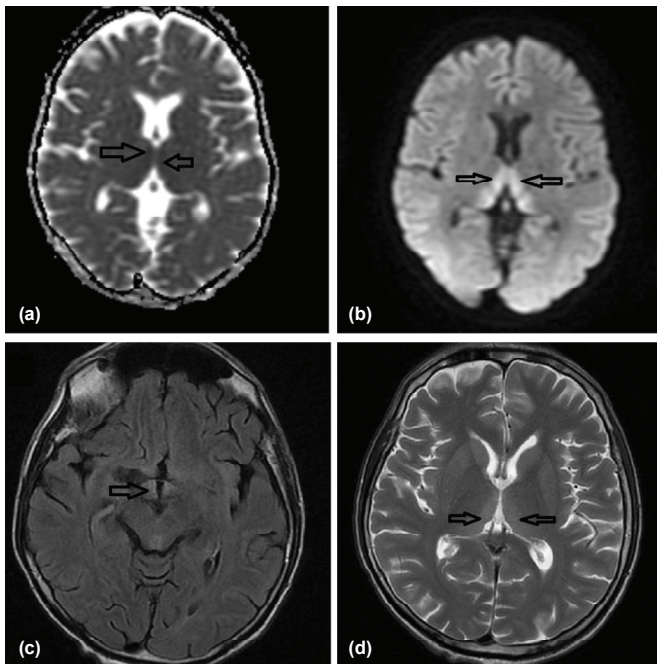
Brain MRI findings: (a) Case 1: MRI axial T2 sequence showing minimal diffusion restriction in the bilateral medial thalamus (black arrows); (b) Case 1: MRI axial diffusion-weighted imaging reveals diffusion brightening in the medial thalamus bilaterally (black arrows); (c) Case 2: MRI T2 sequence displaying signal enhancement in the mammillary bodies (black arrows); (d) Case 2: MRI T2 sequence demonstrating signal enhancement in the bilateral dorsomedial thalamus (black arrows)
